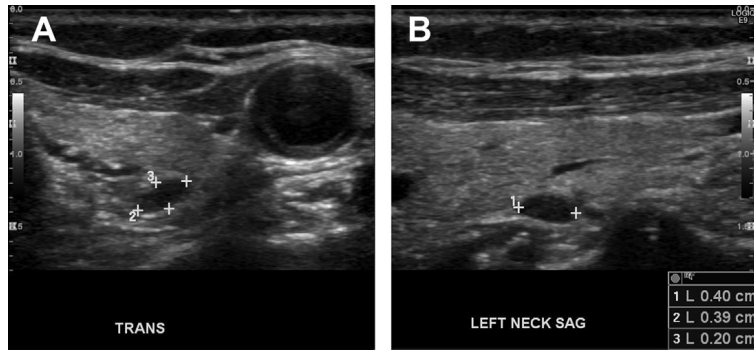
Advantage of ultrasound in patients with thin neck. Transverse (A) and sagittal (B) grayscale images show a small superior parathyroid adenoma (*cursors*).
